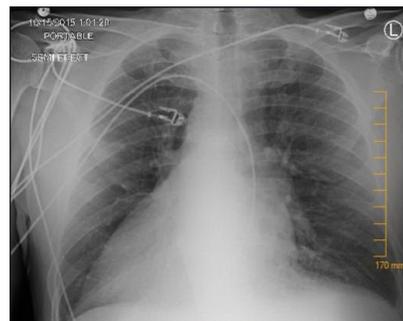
Chest radiograph demonstrating dextrocardia with a right-sided stomach bubble, indicating situs inversus totalis.
